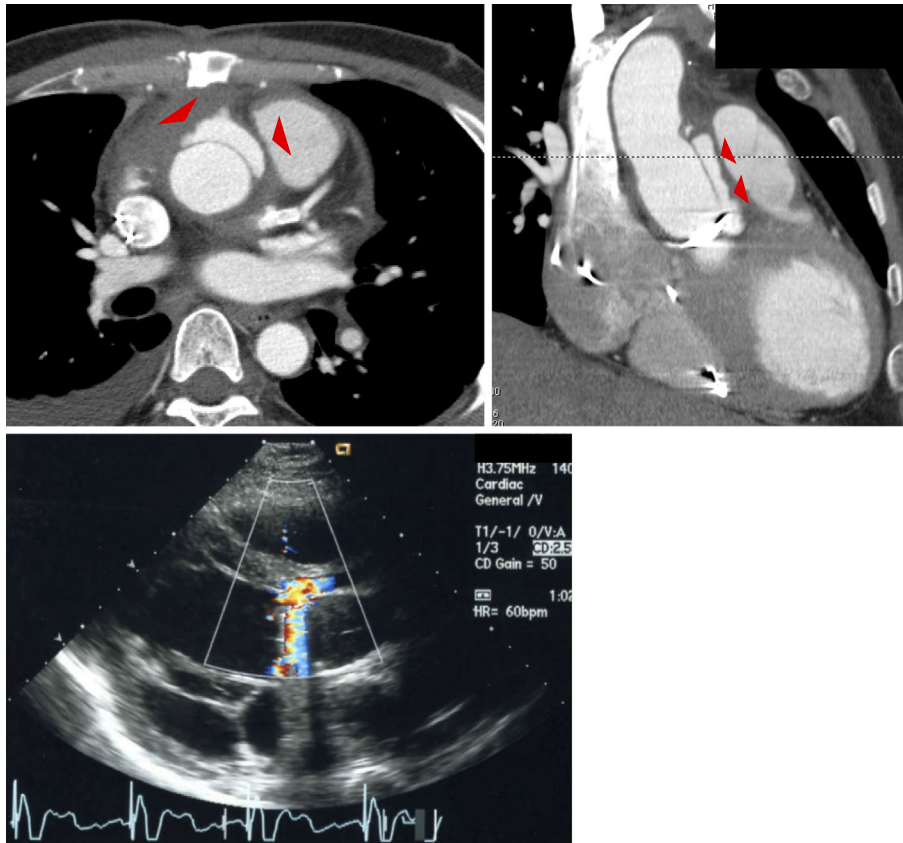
Contrast-enhanced computed tomography (CT) of the chest before the 4th operation. Contrast-enhanced CT revealed a pseudo-aneurysm around the Bentall graft (red triangle). CT: computed tomography
